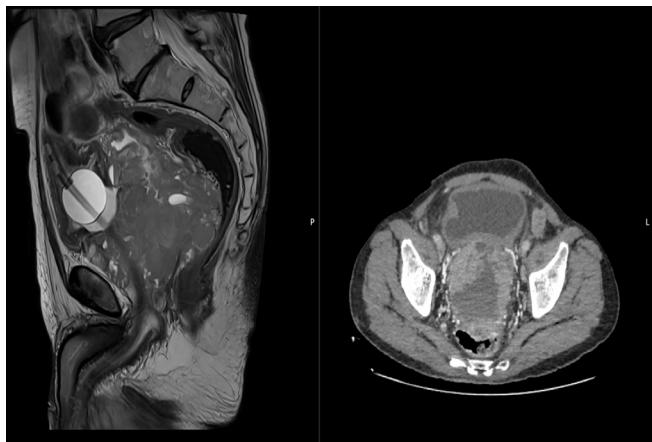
Preoperative pelvic magnetic resonance imaging (MRI) and computed tomography (CT) urography demonstrating a large locally advanced prostatic mass with cystic-necrotic components.
